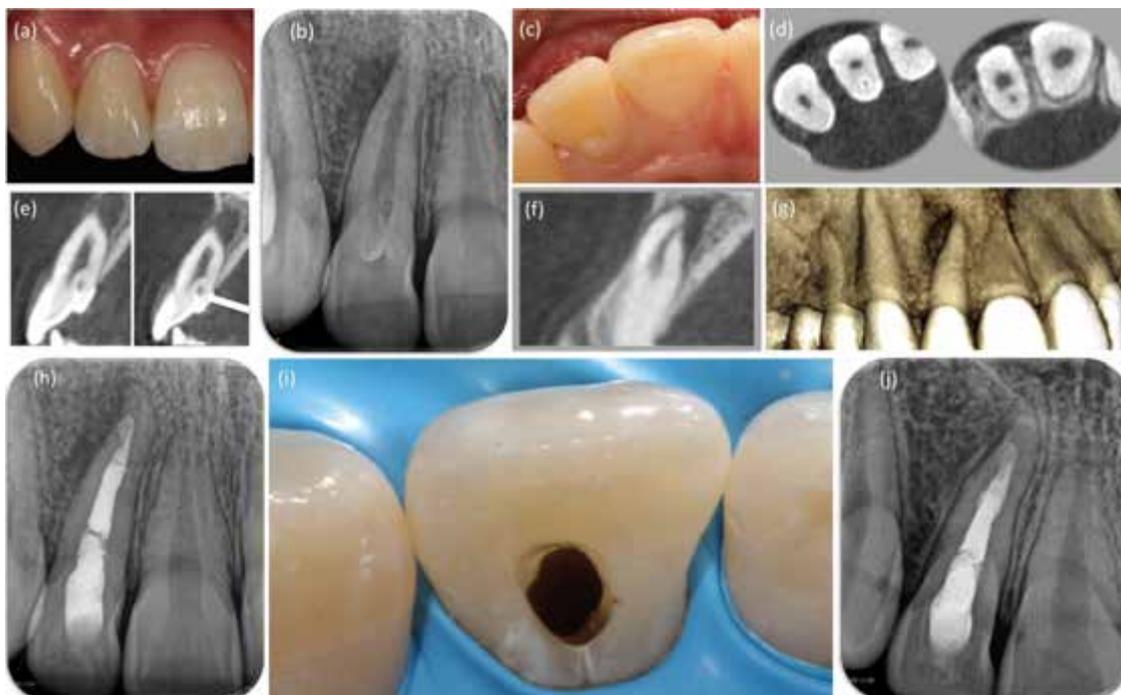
(a) A healthy 16-year-old woman reported episodes of pain and swelling associated with maxillary lateral incisor (tooth 12) over the previous 3 weeks. The crown of the affected tooth was intact but somewhat wider than the bilateral tooth. (b) The tooth did not respond to thermal and electrical stimuli; periodontal probing revealed a normal periodontium. Periapical radiograph showed a mature tooth, and a lateral radiolucency could be seen. (c) A small pit evident in the palatal surface was suspected of being a dens invaginatus. (d, e) Reconstructed cone beam computed tomography (CBCT) (ProMax 3Ds; Planmeca Oy, Helsinki, Finland) images confirmed the diagnosis of a dens invaginatus. The axial and sagittal views showing the enamel-line invagination (white arrow) and the relationship between the main root canal. (f) Note the lateral exit of the root canal. (g) Three-dimensional CBCT reconstruction; buccal view. (h) Post-operative radiograph. (i) Final access opening. (j) A recall periapical radiograph taken 12 months after the initial appointment. Note the complete periapical healing.
